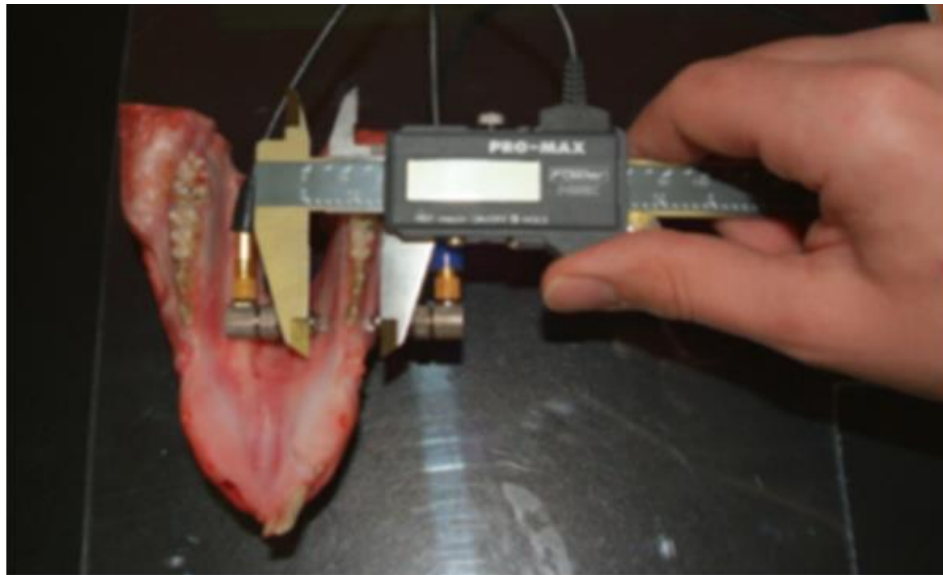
The first prototype for proof of concept evaluation. A measurement caliper with attached ultrasound transducers.
